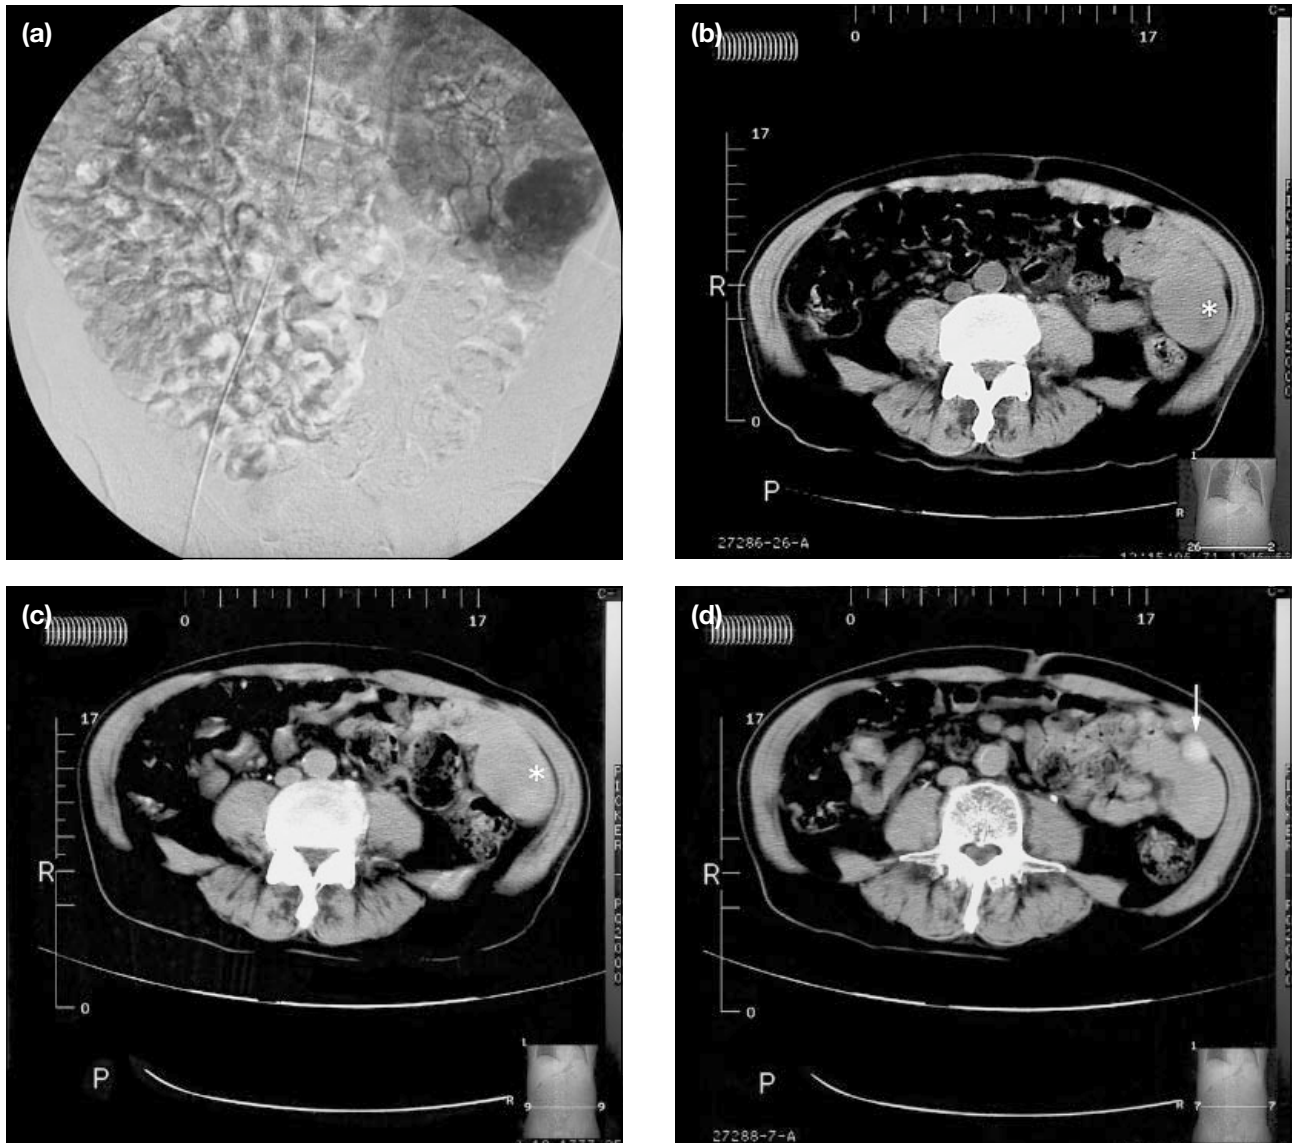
(a) Angiographic appearance of a small bowel stromal tumour; (b) plain CT abdomen scans prior to angiography shows a soft tissue mass in the left lower abdomen (white asterisk) suggestive of a small bowel tumour; (c) postangiography plain CT abdomen shows a heterogeneous soft tissue mass (white asterisk); and (d) contrast extravasation into the small bowel loop (white arrow). Surgery confirmed the presence of a small bowel stromal tumour protruding into gut lumen.
